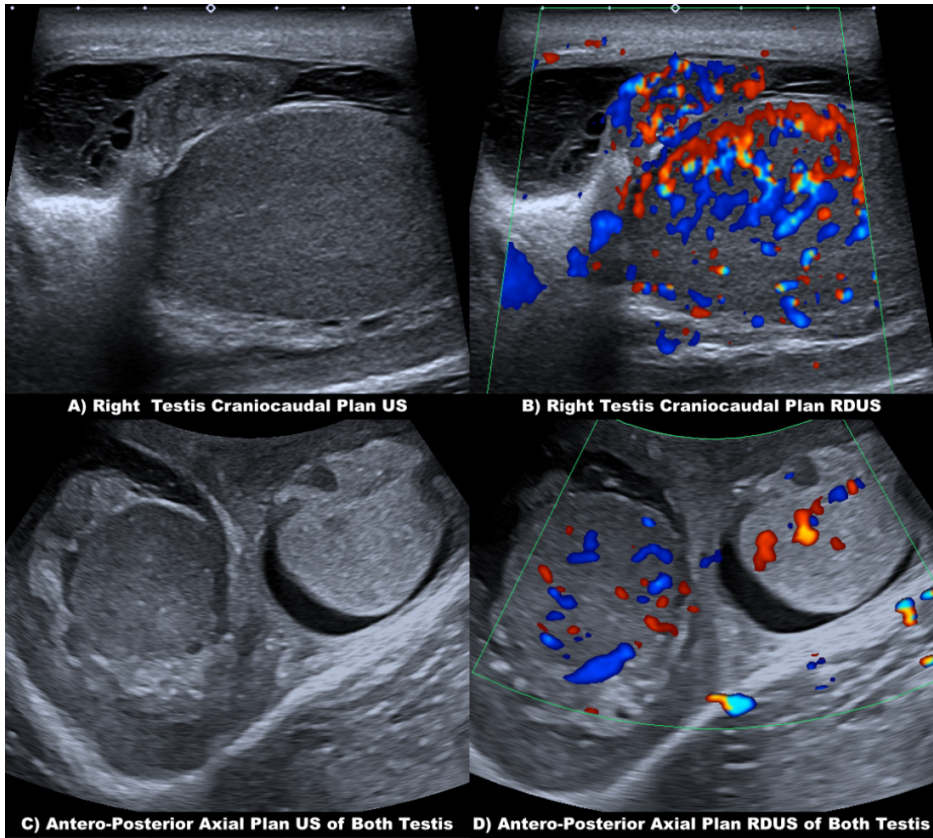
A 57-year-old male patient complained of scrotal pain, swelling, and redness. US and CDUS were performed. A-D) In US and CDUS imaging with high-frequency linear and low-frequency convex transducers, the right testis and epididymal parenchyma appear hypoechoic heterogeneous compared to left testis and epididymis, and their vascularity is noticeably increased. On the right, the intrascrotal fluid is increased and contains echogenic septa. Control US and CDUS were performed on the patient diagnosed with epididymo-orchitis because his complaints increased 2 weeks after the treatment was started. MRI was applied to the patient with a fistulous collection under the skin.
